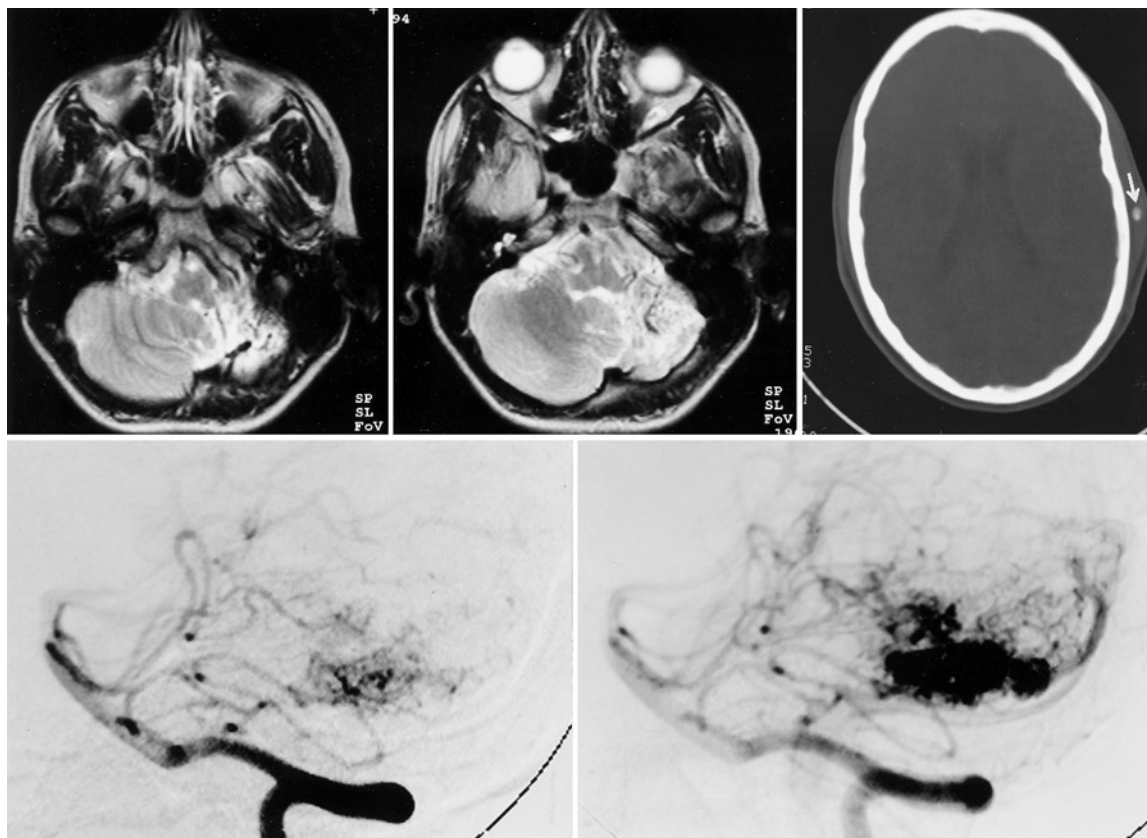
Case 3. Magnetic resonance (MR) images, computerized tomography (CT) scan, and vertebral angiograms in the proband. The MR images (*upper left and center*) show the left cerebellar arteriovenous malformation (AVM) and hypoplasia of the left cerebellar hemisphere and tonsil. The CT scan (*upper right*) shows a subcutaneous phlebolith (*arrow*) from a subcutaneous hemangioma in the left temporal region ipsilateral to the AVM. A small vascular lesion was also present, largely subcutaneous, in the ipsilateral palm. Vertebral angiograms (*lower left and right*) confirm the cerebellar lesion as an AVM.
